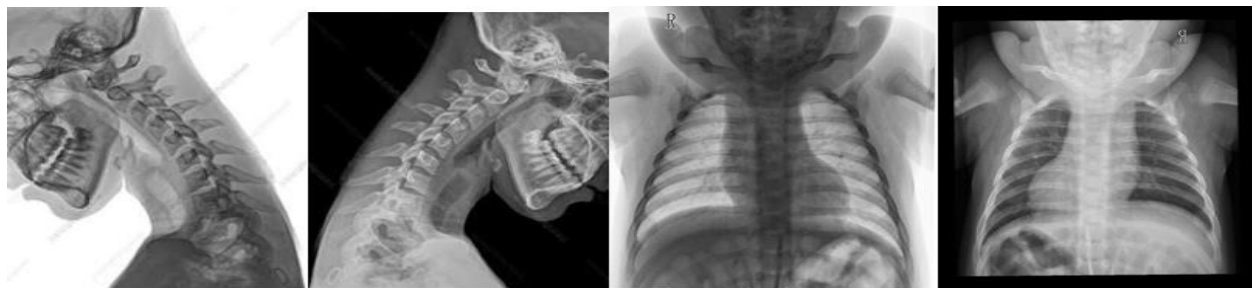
Neck and chest radiographic basic negations; from left, neck negated image, neck flopped image, chest negated image and chest flopped image.
